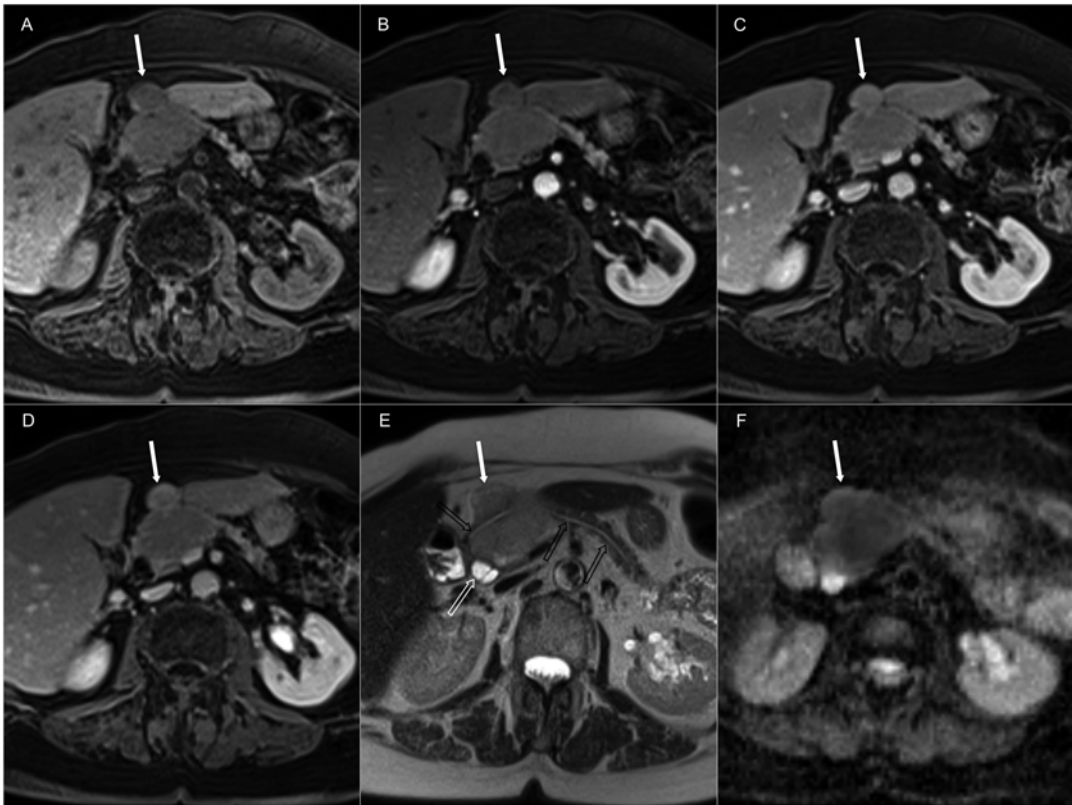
MRI examination of a patient with a nonhypervascular neuroendocrine tumor in the proximal body of the pancreas. On fat-saturated T1-weighted images before (a) and post contrast (b–d), the tumor (white arrow) does not show hypervascularity, a finding more common in nonfunctioning PNETs. On the T2-weighted HASTE
